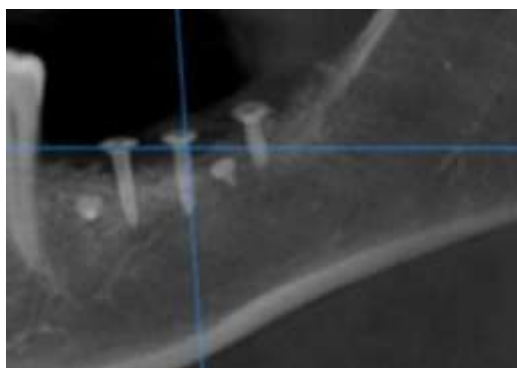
A 6-months follow up radiograph showing the vertical amount of bone gain.
